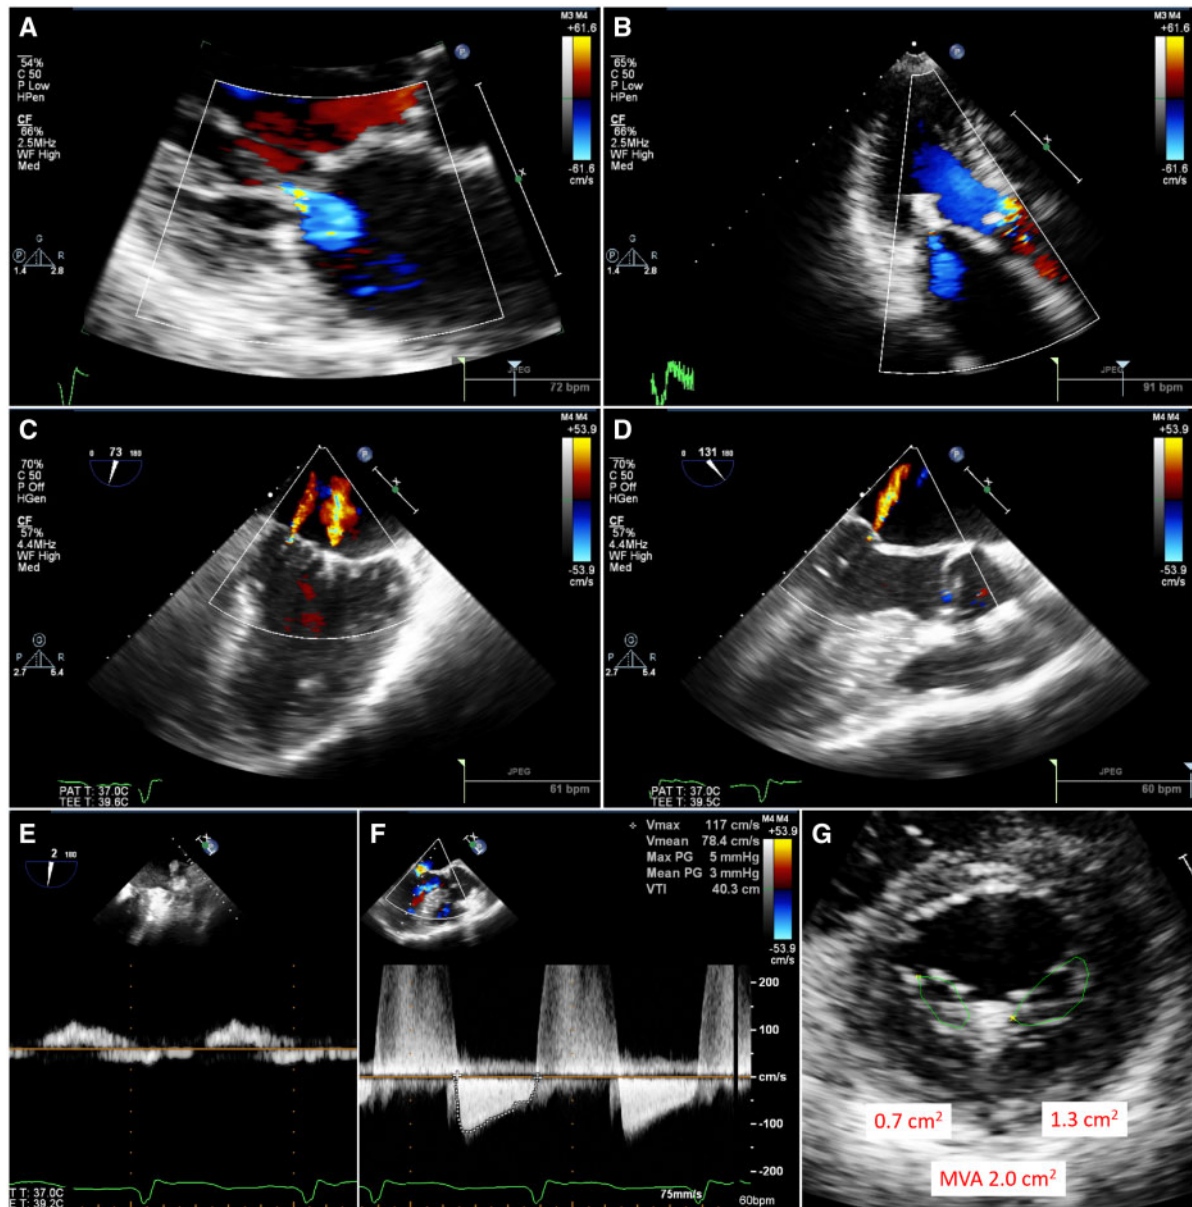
Severe mitral regurgitation demonstrated on (A, B) transthoracic echocardiographic parasternal long axis and apical 3-chamber views, as well as (C, D) transoesophageal echocardiographic intercommisural and left ventricular outflow tract views. (E) Pulmonary vein systolic flow reversal. (F) Transmitral mean pressure gradient of 2 mmHg. (G) Mitral valve area of 2.68 cm<sup>2</sup> by planimetry.
